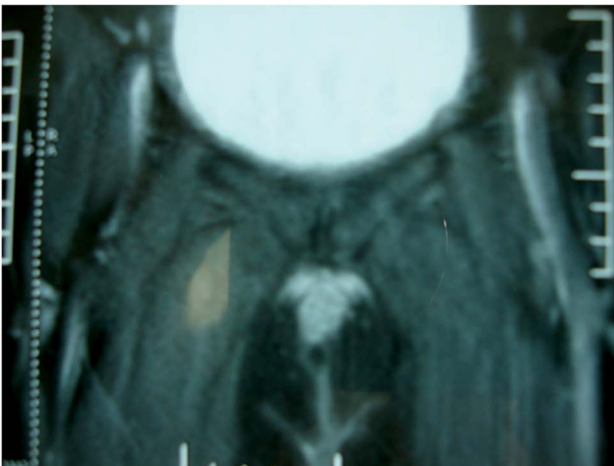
MRI Pelvis T2 weighted image showing hypointense muscle layer
